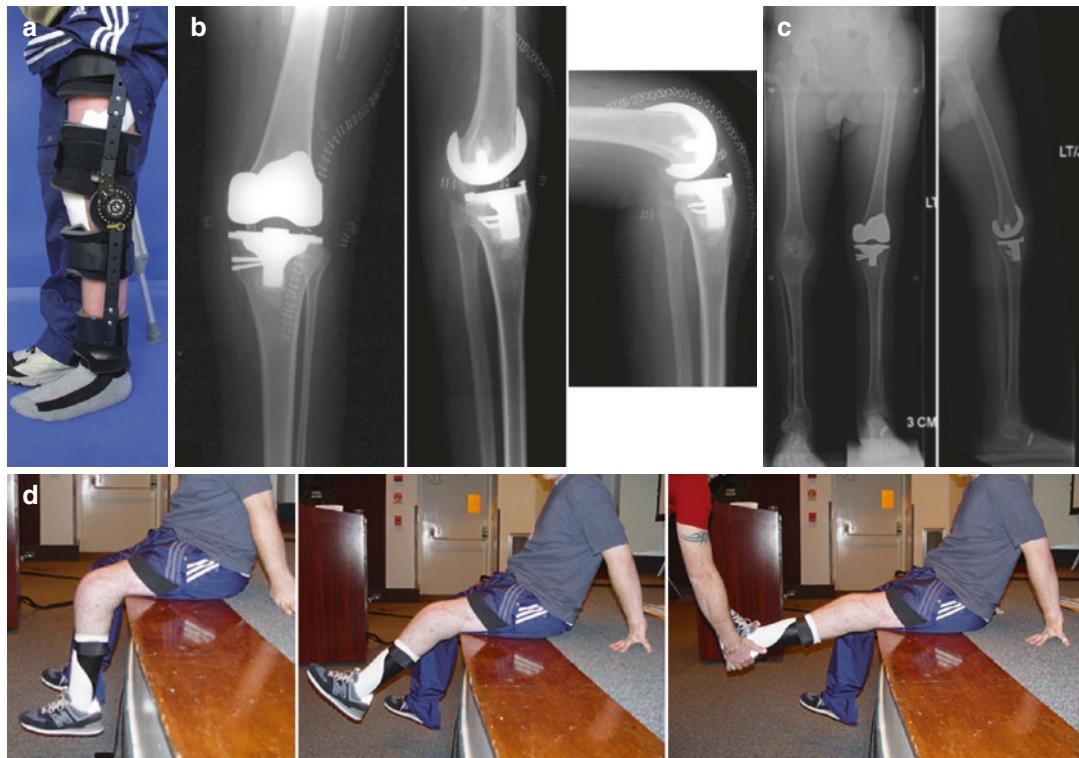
Case 1: (a) After surgery the patient ambulates in a lockable knee brace until the patient regains quadriceps control and can walk without the knee buckling. (b) Immediate postoperative AP (left) and lateral (middle) radiographs of the knee in extension and lateral radiograph of the knee in flexion (right). Note the two Hemovac drains in the medial and lateral gutters on the AP radiograph. Also note the skin was closed with staples to resist the continuous knee flexion with the continuous passive
